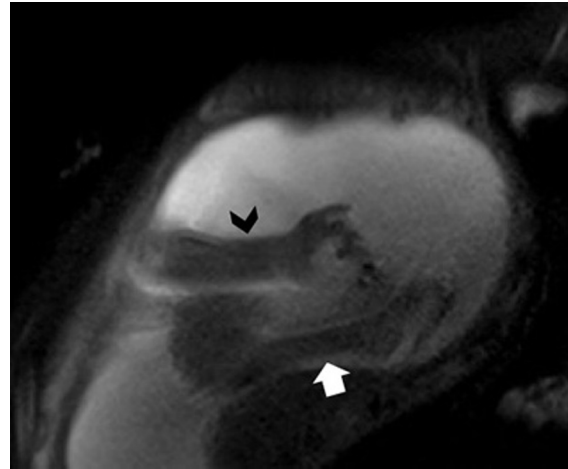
MRI shows normal size of fetal forearm (black chevron) and sarcopenia of leg (white arrow).
